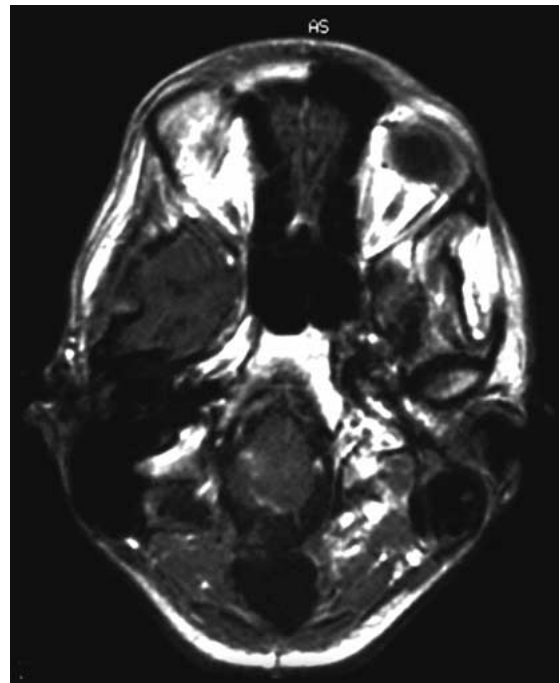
Gadolinium enhanced MRI scan after PDT.
